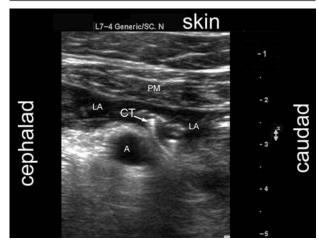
FIGURE 1ii Spread of local anesthetic between vascular structures and pectoral muscle. A distinct tissue barrier appears to divide the plane containing the vessels from that where injection occurs. LA = local anesthetic; PM = pectoralis muscle; A = axillary artery; CT = catheter tip.
